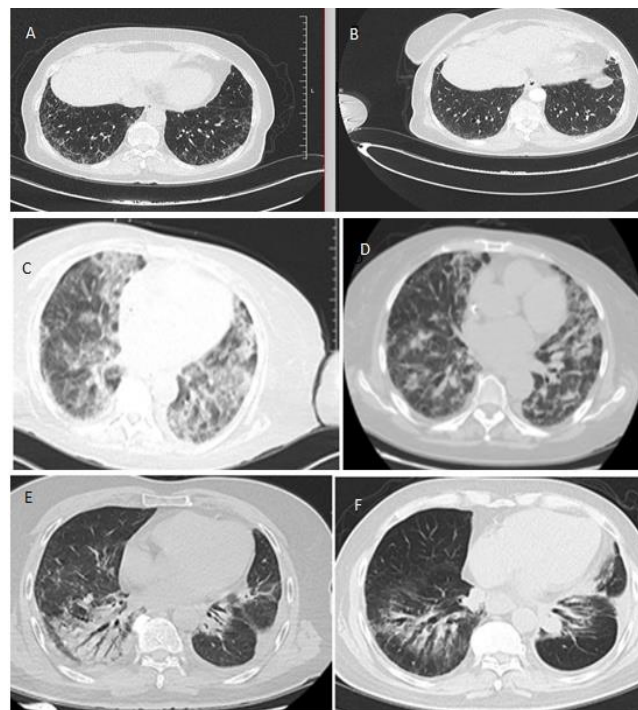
Diagnostic and follow-up thoracic CT slices of cases 1, 2, and 3. (A) Case 1 Thoracic CT at diagnosis, (B) Case 1 Thoracic CT one year after treatment, (C) Case 2 Thoracic CT at diagnosis, (D) Case 2 Thoracic CT one month after treatment, (E) Case 3 Thoracic CT at diagnosis, (F) Case 3 Thoracic CT three months after treatment.
